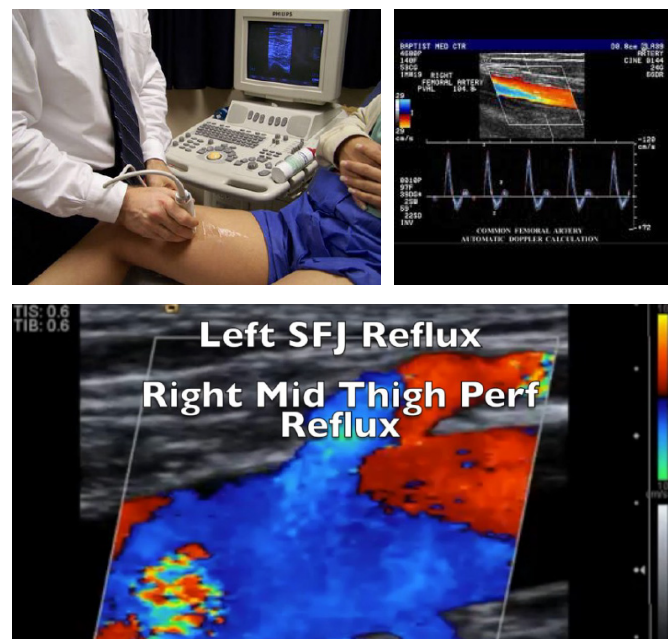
Colour Doppler/Duplex
